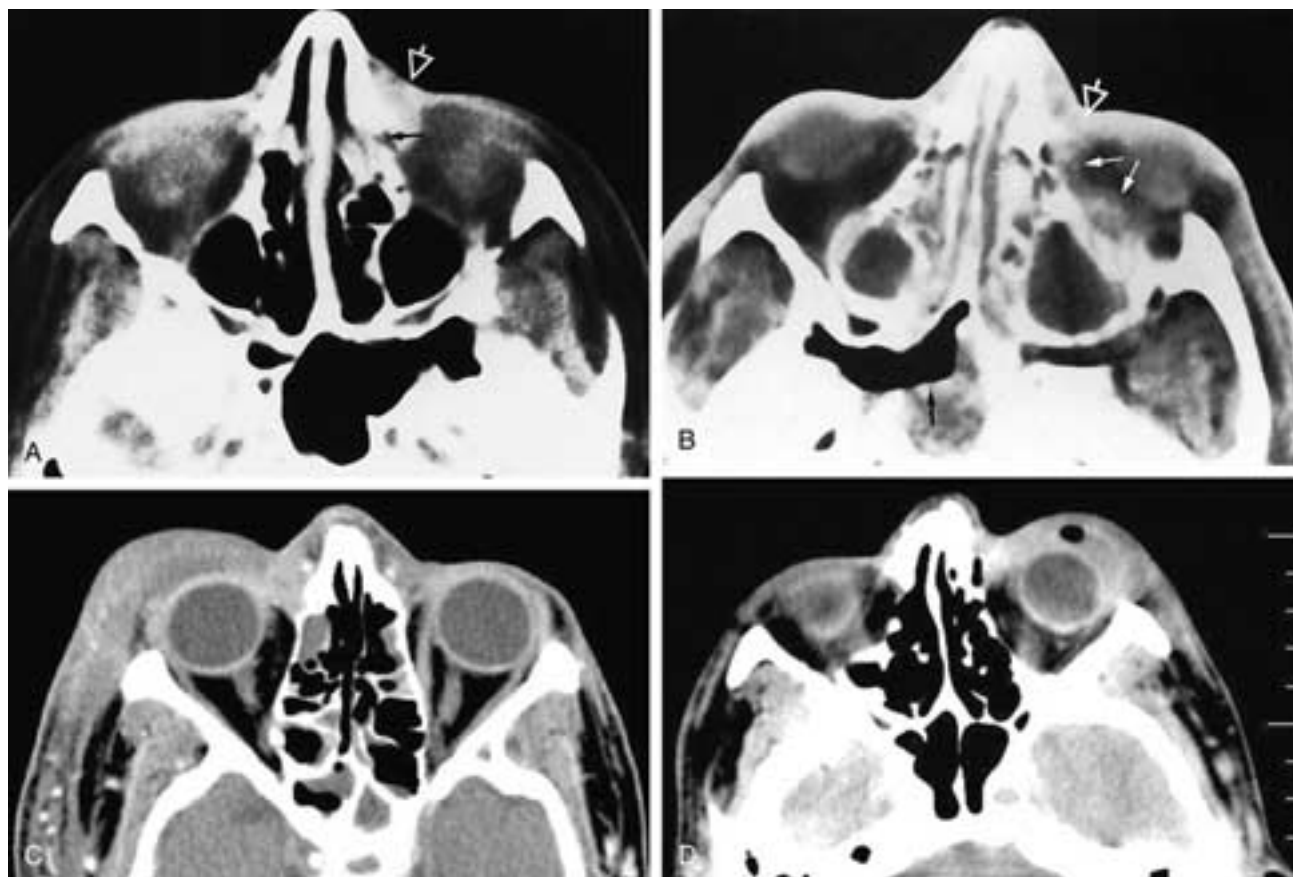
CT differentiating preseptal from orbital inflammatory lesions (which may be difficult on clinical examination). Multiple patients. A, Soft-tissue mass in the left inner canthus (*open arrow*) with faint peripheral enhancement contiguous with the left nasolacrimal fossa (partially obscured by beam-hardening artifact) (*thin arrow*). Mass is localized to the preseptal tissues. Pathology: chronic dacryocystitis with mucocele formation. B, Soft-tissue prominence (*open arrow*) of the left inner canthus, clinically noted on axial CT to involve the medial orbital soft tissues and inferior rectus muscle (*thin white arrows*). Pansinus opacification with fluid level in the right sphenoid sinus (*black arrow*). Sinusitis with left orbital cellulitis. C, Second patient. Preseptal orbital cellulitis secondary to dacryocystitis. Note the sharp posterior border of the inflammatory process due to orbital septum attachment to the posterior lacrimal crest. D and E, Third patient. Axial (D) and coronal (E) CT scans show a preseptal left orbital abscess containing air and pus. Soft-tissue edema extends medially to abut the normal air-containing lacrimal sac.
